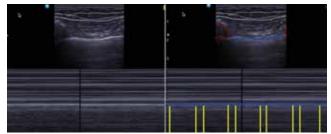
Lung pulse. The scanning image, upper: B-mode, lower: M-mode. Left: The ultrasound probe is placed transversely in an inter-space between two ribs during normal ventilation. Right: if the lung is inflated but not ventilated, every heartbeat that is transmitted though the inflated lung causes the two pleural layers (blue) to move a bit with each heartbeat, thereby creating the "lung pulse" artifact (yellow lines). Source: www.airwayelearning.com
